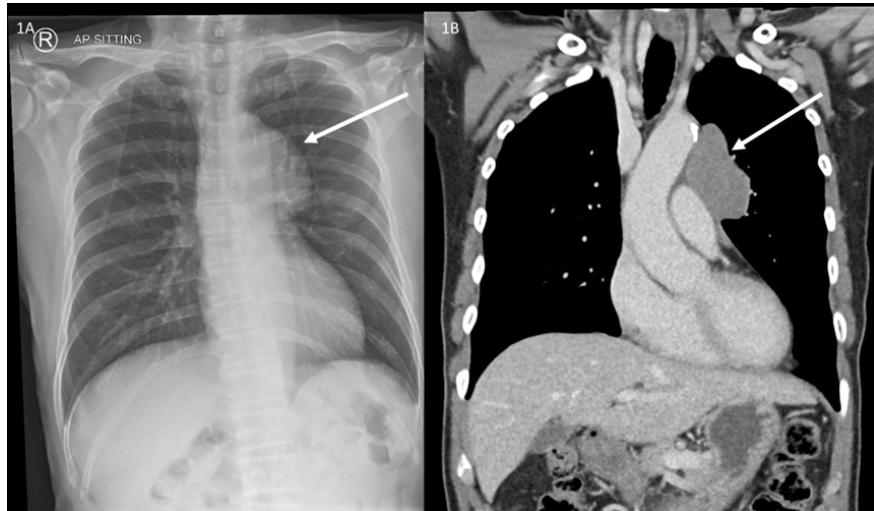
AP Chest radiograph demonstrating a mass overlapping the left hilum suggestive of an anterior mediastinal mass (white arrow).
